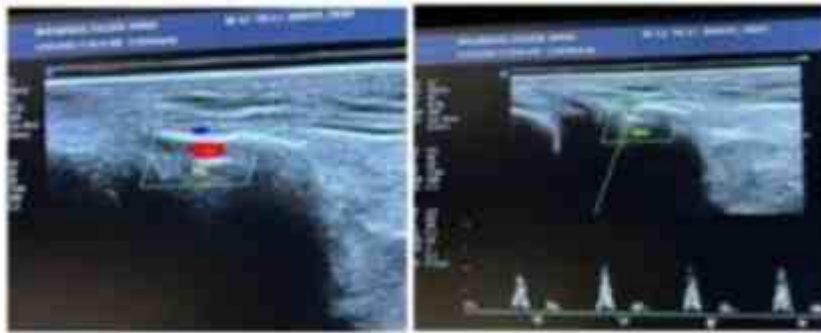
Same above patient (A) Wall thickening along Dorsalis Pedis artery (DPA) with laminar forward blood flow on Color Doppler scan, (B) showing normal triphasic waveform on spectral Doppler.
